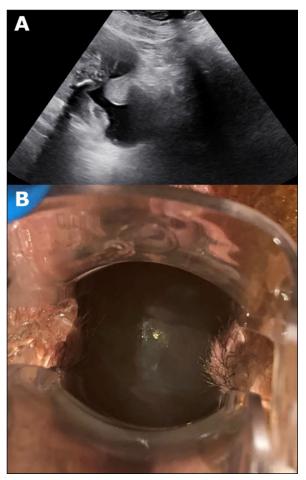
A representative case with protruding type of prolapsed fetal membranes. A, An ultrasound image of an open cervical canal and protruding type of prolapsed fetal membranes. B, A vaginal image of protruding type of prolapsed fetal membranes from the same case as mentioned above.
